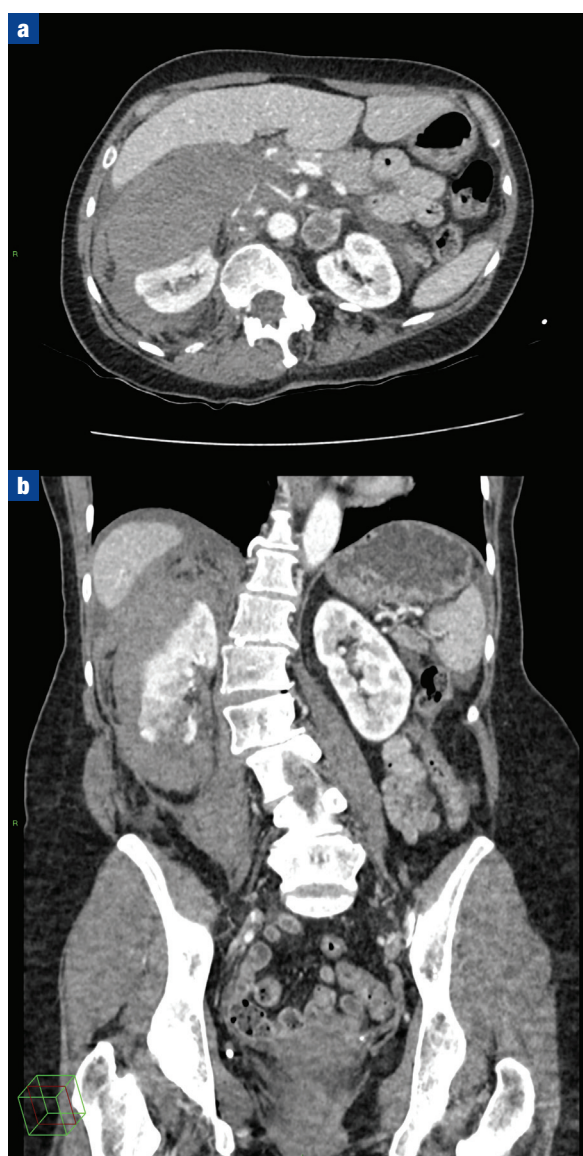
a. Axial and (b) coronal computed tomography images demonstrating a 'shattered' kidney with surrounding haematoma.
